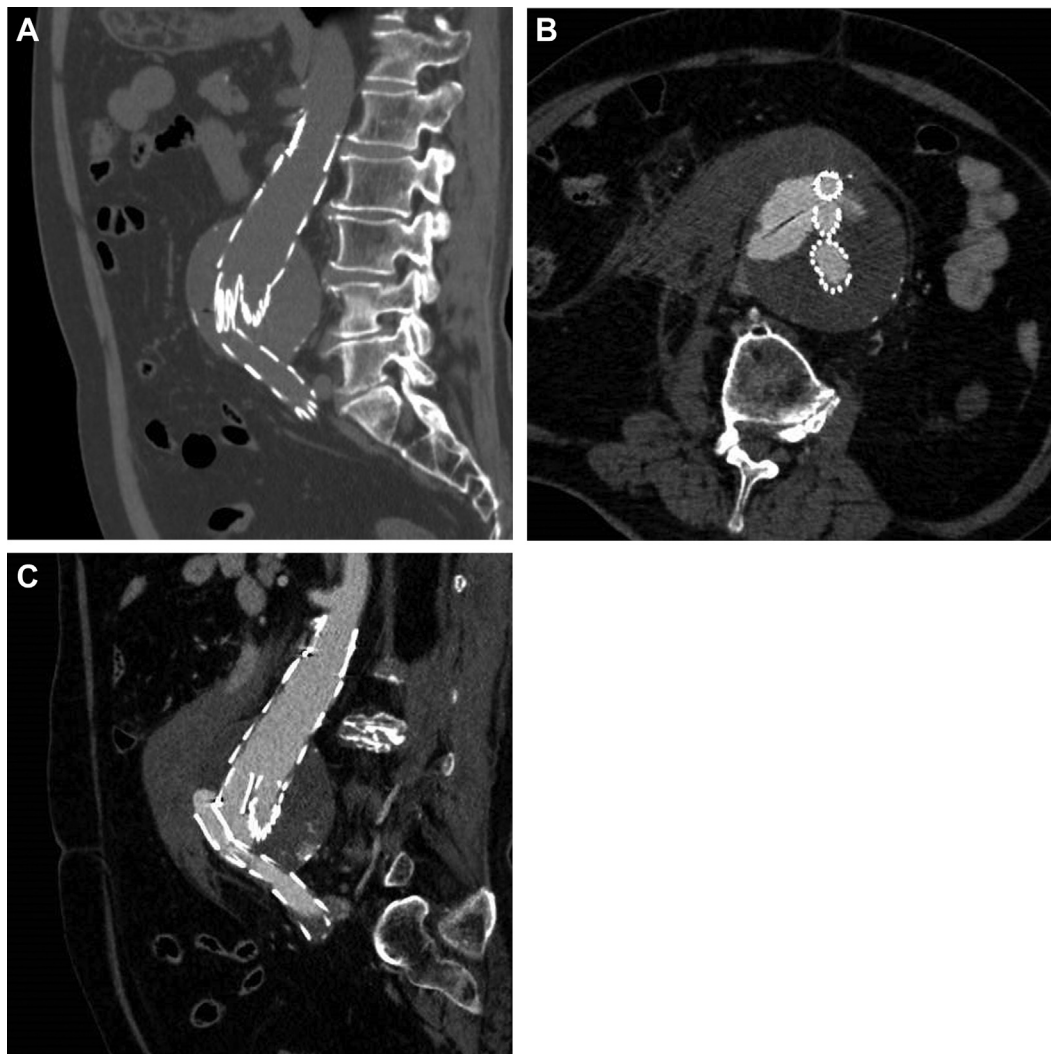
A, Computed tomography scan from 6 years before the current presentation, after endovascular aortic repair, showing that only one half of the first stent of the contralateral limb had overlapped with high angulation formed where the line of the main body had crossed the line of the contralateral limb. B, Contrast-enhanced computed tomography scan showing a major endoleak, a large retroperitoneal hematoma, and three parts of the stent graft limbs. C, Contrast-enhanced computed tomography scan with sagittal section showing disconnected stent graft limb.
